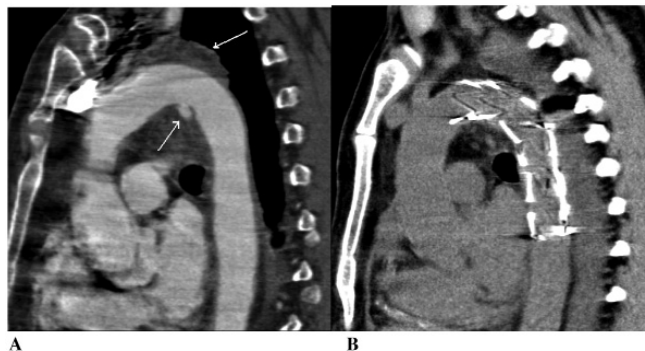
A, Computed tomographic scan of extravasation of contrast material at the descending aorta (minor curvature) surrounded by the hematoma (major curvature). B, One month follow-up computed tomographic scan of aortic endovascular stent graft showing no endoleak.
